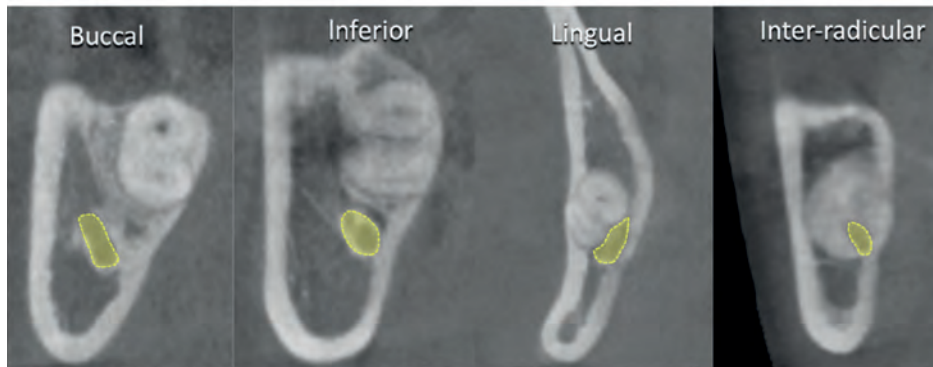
CT scan images of root/IAC relationships
